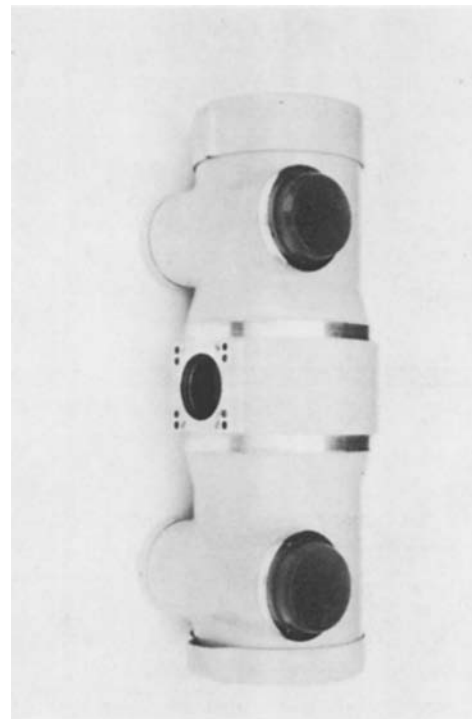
Typical medical X-ray tube housing.
